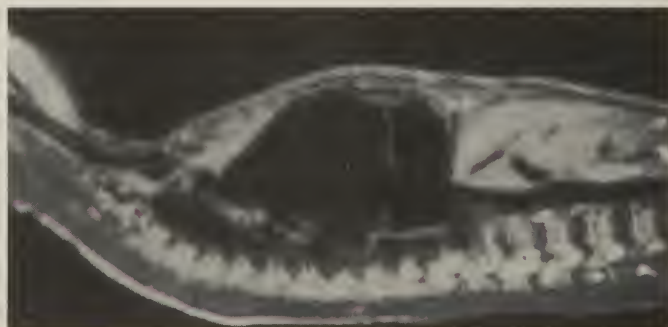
An MRI depicts a 9-cm diameter Marfan aneurysm of the aortic root in a nine-year-old boy.
